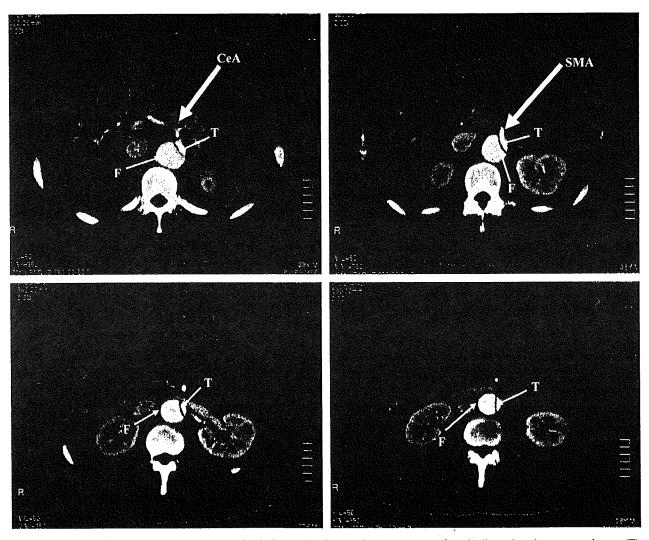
A computed tomography (CT) scan obtained 12 months after the first occurrence of aortic dissection shows a true lumen (T) compressed by false lumen extending from the distal arch to the right common iliac artery. The celiac arteries (CeA), the superior mesenteric arteries (SMA), and the left renal arteries originate from the true lumen, whereas the right renal artery originates from the false lumen.
